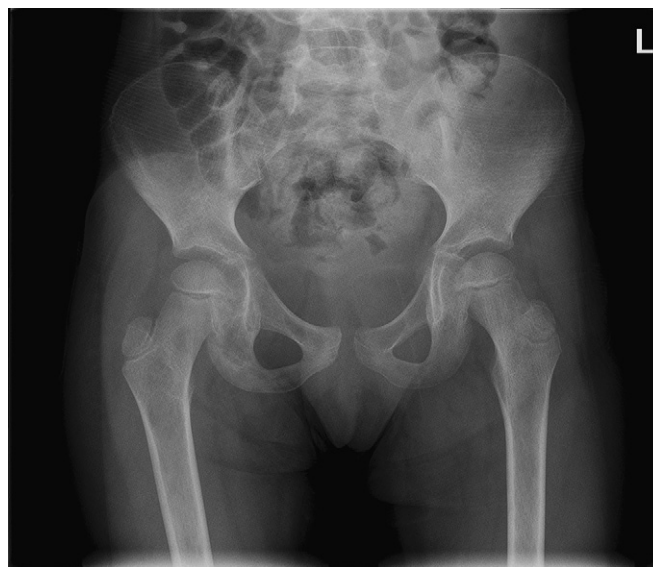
Anteroposterior (AP) pelvic radiograph.
